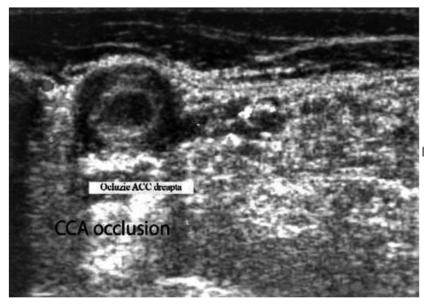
Large vessel GCA. Duplex ultrasound
